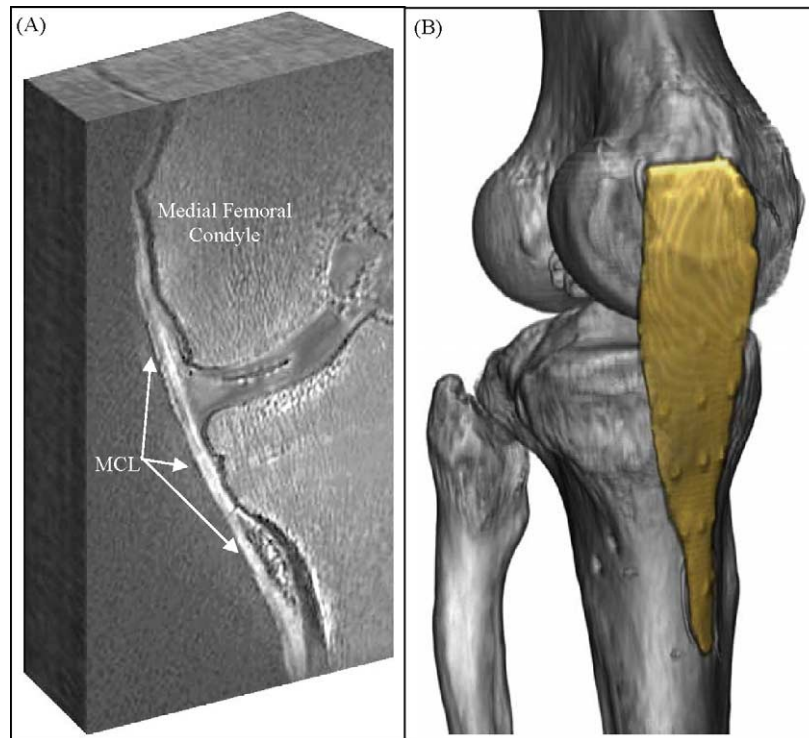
Volumetric images of the human medial collateral ligament obtained from MRI (left) and CT (right). MR image geometry: Cropped to 180×340 ($56 \text{ mm} \times 106 \text{ mm}$), 0.8 mm slice thickness; T2 processed dual echo image, $TE1 = 1.63 \text{ ms}$, $TE2 = 8.61 \text{ ms}$. CT image geometry: 512×512 acquisition matrix, 100 mm FOV, 1 mm slice thickness.
